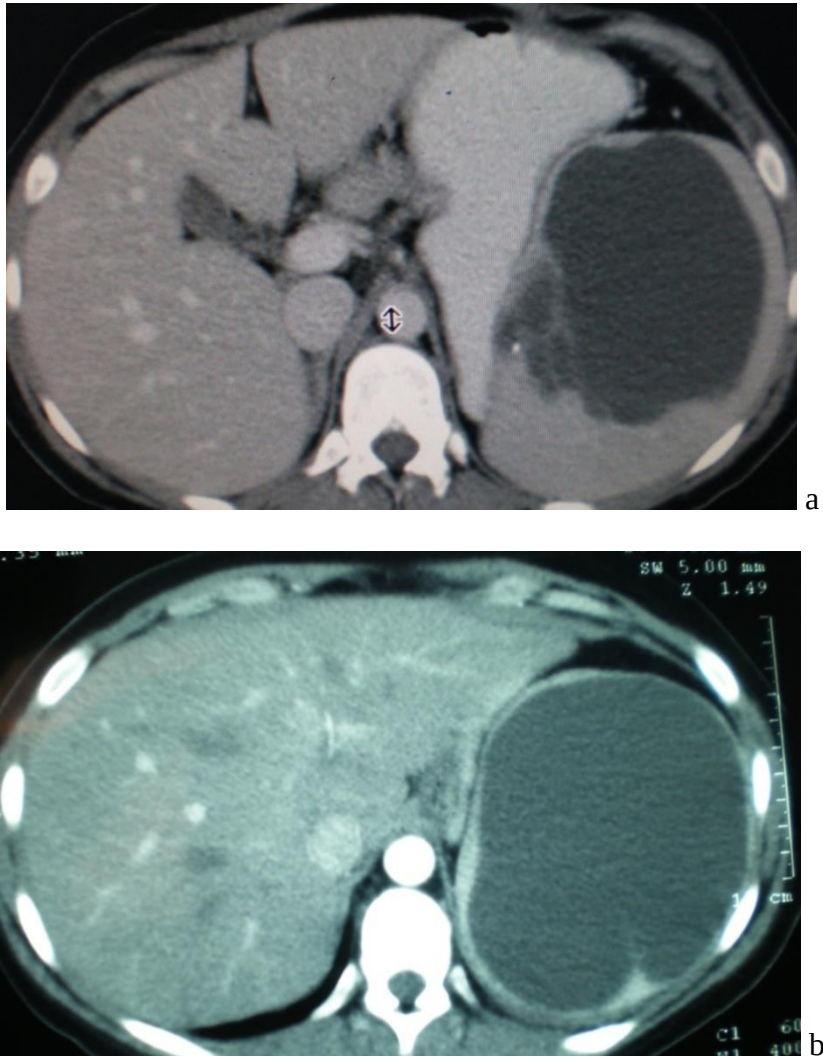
a, b : CT scan showed giant hydatid cyst with smooth wall and septation and multiple eccentric daughter cysts.
